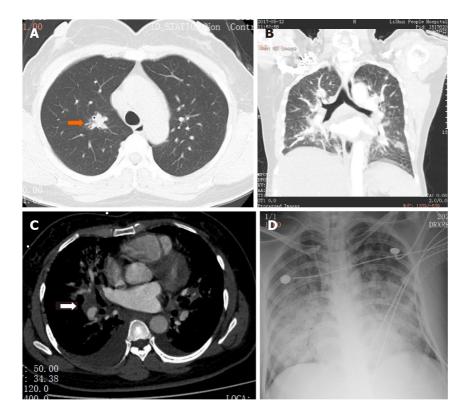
A 40-year-old woman presented with a 6-d history of fever (up to 38.0 °C), non-productive cough, and exertional dyspnea. A: Chest computed tomography (CT; transverse section) at admission showed a solid nodule (arrow), 15 mm in diameter, with a poorly defined boundary in the upper lobe of the right lung. Several smaller solid nodules were seen in both lungs; B: Chest CT at admission (coronal section); C: A pulmonary CT angiogram showed normal pulmonary vasculature, but diffuse patchy shadows with poorly defined boundaries were seen in both lungs, with bilateral pleural effusion and an enlarged lymph node (25 mm × 21 mm) in the right hilum; D: Chest X-ray showed diffuse patchy shadows throughout both lungs.
